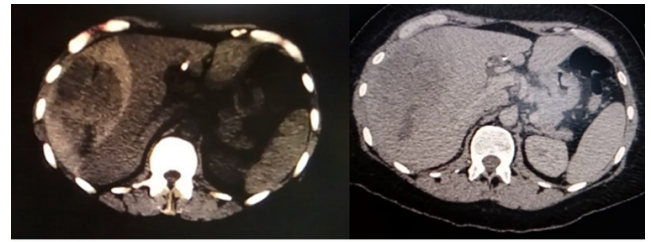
Computed tomography in axial plane on admission with a subcapsular hematoma involving hepatic segments VI, VII, and VIII, measuring 205 x 148 x 77 cm. A) arterial phase B) portal phase without enhancement.
